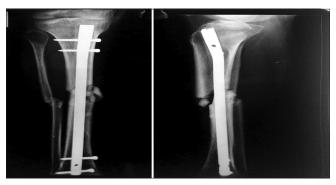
Pre-operative X-ray images of infective non-union with implant *in situ*
